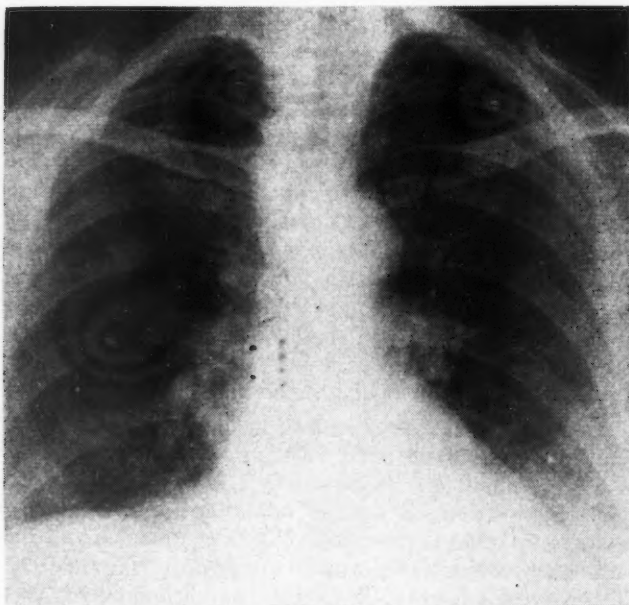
Second chest radiograph (October 28, 1958), 10 days later, shows clear lung fields and marked decrease in cardiac size.
